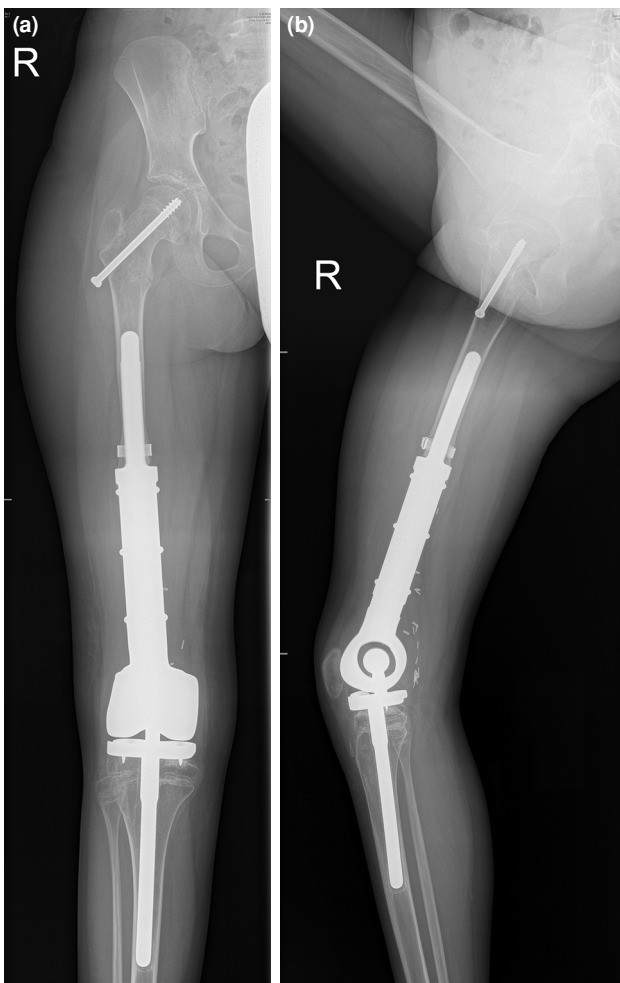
Follow-up images in the first year (a) anteroposterior radiograph (b) lateral radiograph.
